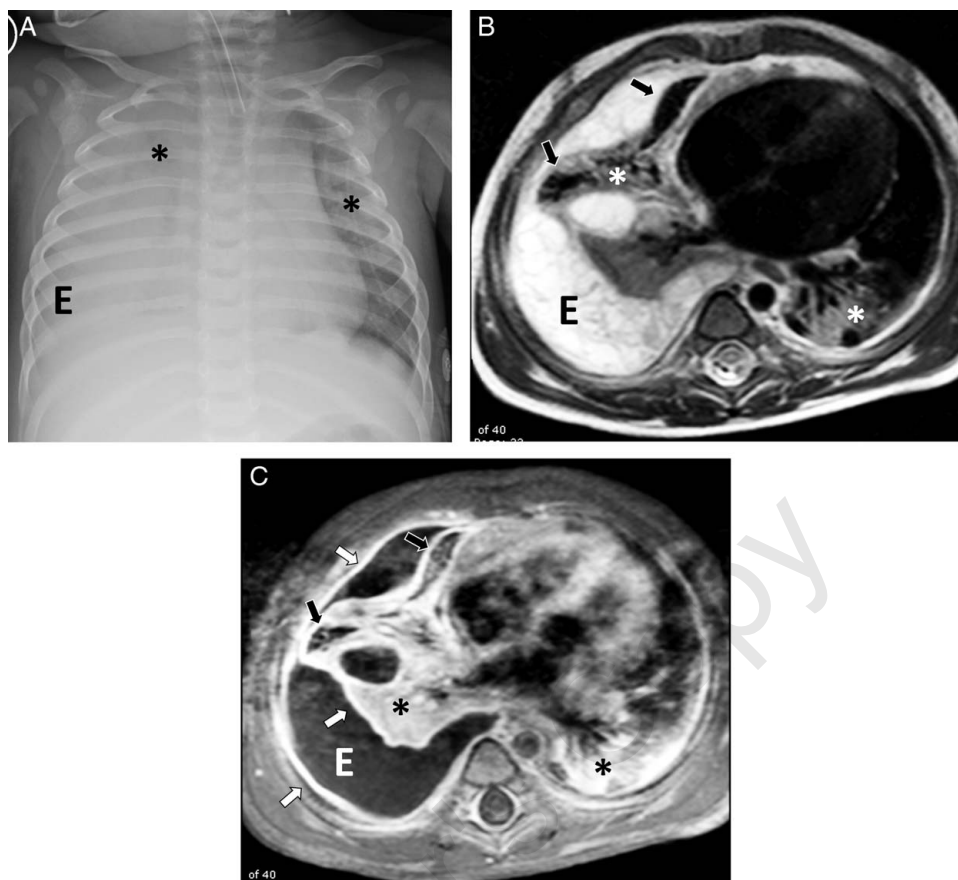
A 8-month-old boy with necrotizing pneumonia and empyema. A, Frontal chest radiograph demonstrates bilateral pulmonary opacities (asterisks) and large right pleural effusion (E). B, Axial nonenhanced T2-weighted MRI shows hyperintense signal within bilateral lungs (asterisks) surrounding regions of low signal intensity (black arrows) within the right middle lobe corresponding to regions of necrosis and large right pleural effusion (E) containing septations compatible with empyema. C, Axial enhanced T1-weighted fat suppressed MR image shows hyperenhancement within bilateral lungs (asterisks) surrounding regions of nonenhancement (black arrows) within the right middle lobe corresponding to regions of necrosis and large right pleural effusion (E) with thickening and enhancement of pleura (white arrows) compatible with empyema.
